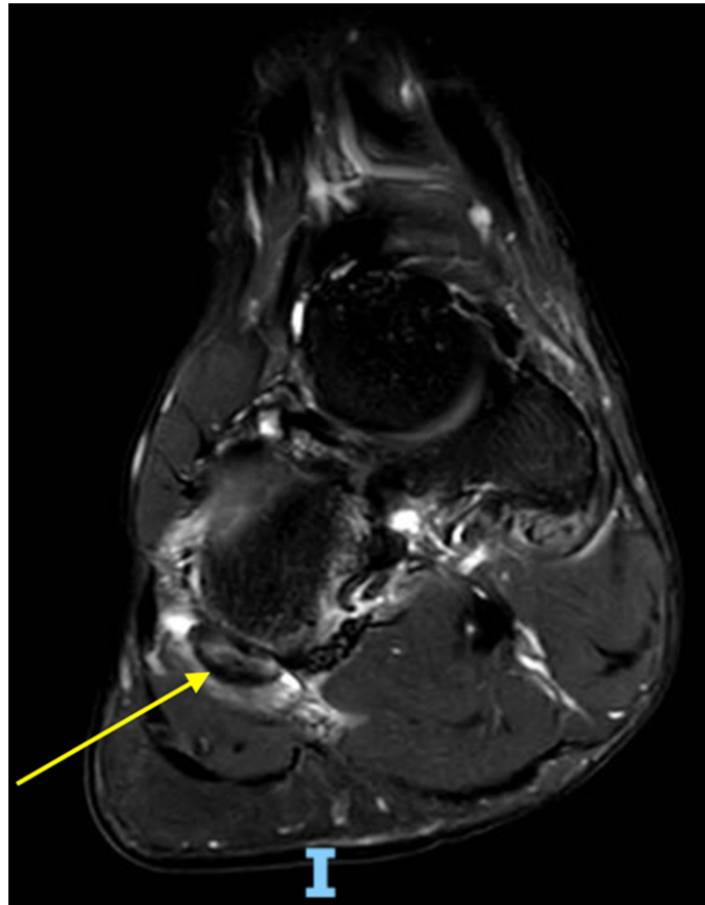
Follow-up MRI (6 weeks): decreased hyperintensity and restored tendon continuity (yellow arrow).
